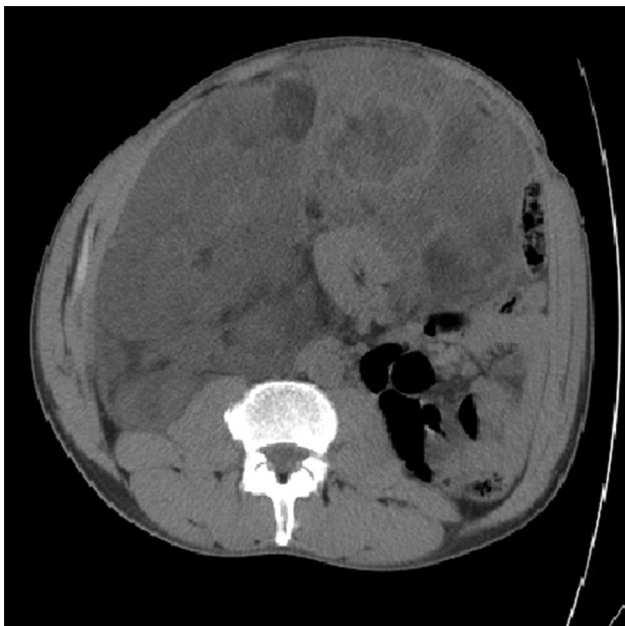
CT scan showing the large retroperitoneal sarcoma. CT, computed tomography.
